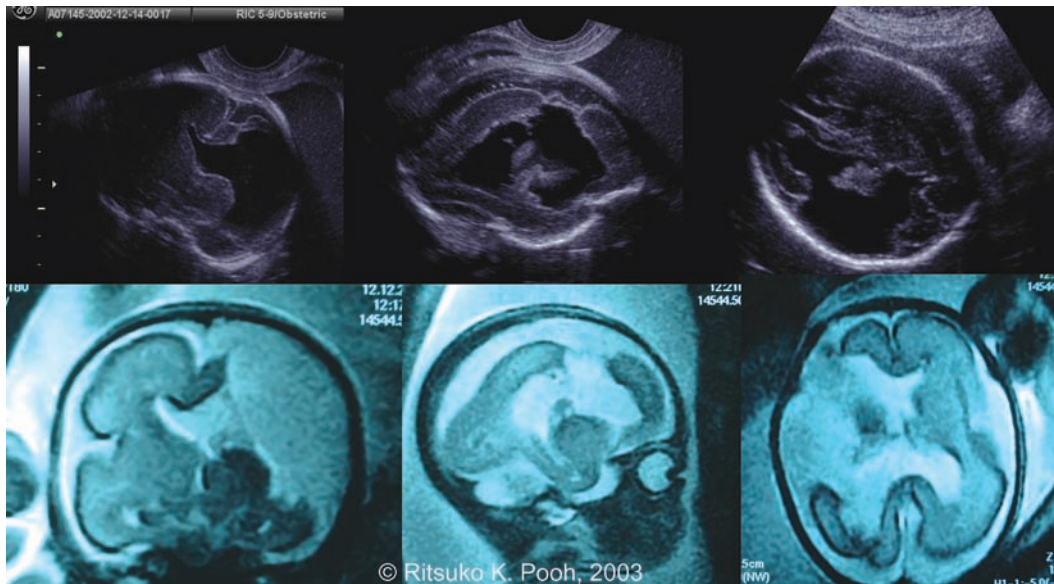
Fetal ultrasound and MR images of porencephaly at 25 weeks of gestation. (Upper left) Transvaginal ultrasound coronal image. Defect of parietolateral part of the unilateral cerebrum. This case has also absent septum pellucidum. (Upper middle) Parasagittal ultrasound image. Porencephalic part is fused with the unilateral ventricle. Echogenicity of inside ventricular wall indicates intraventricular hemorrhage. (Upper right) Transabdominal ultrasound axial image. (Lower) Fetal MR images on the same day. Coronal, parasagittal, and axial sections from the left side.
